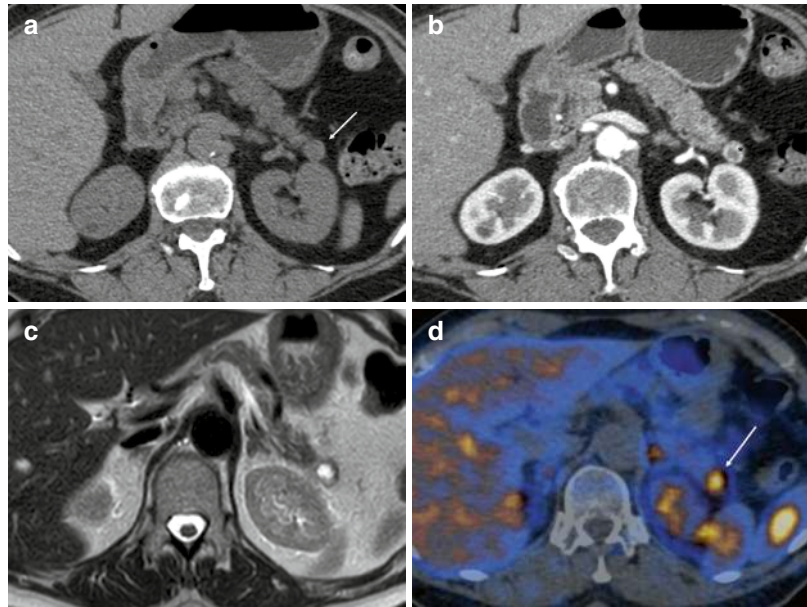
A 64-year-old woman with cystic pancreatic neuroendocrine tumor (PNET). (a) Precontrast CT shows a slightly hypodense lesion in the pancreatic tail (*arrow*). (b) Arterial phase CT demonstrates a well-defined hypodense fluid lesion with a rim of well-vascularized enhancing tissue. (c) T2-weighted image shows better the cystic nature of the lesion. (d) The mass is hypermetabolic on GA-68 DOTA-TOC PET (*arrow*)
